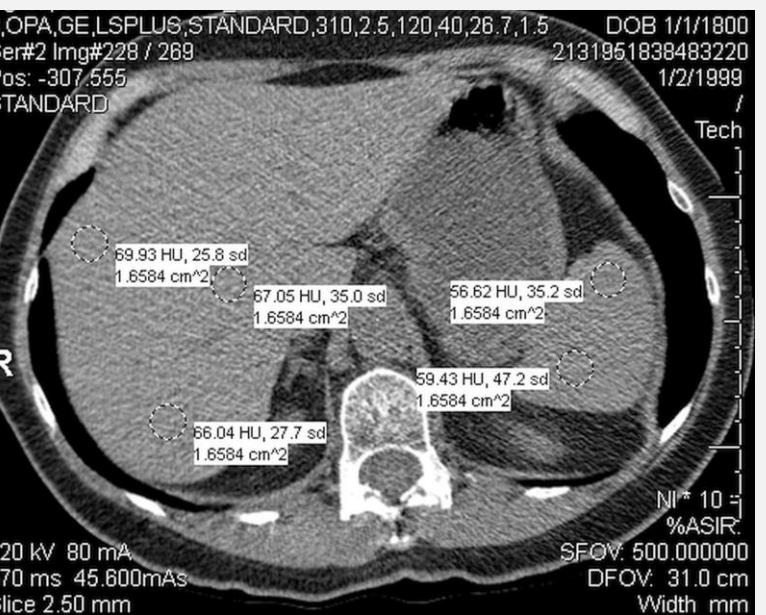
Axial CT scan shows liver and spleen attenuation (density) measurements
